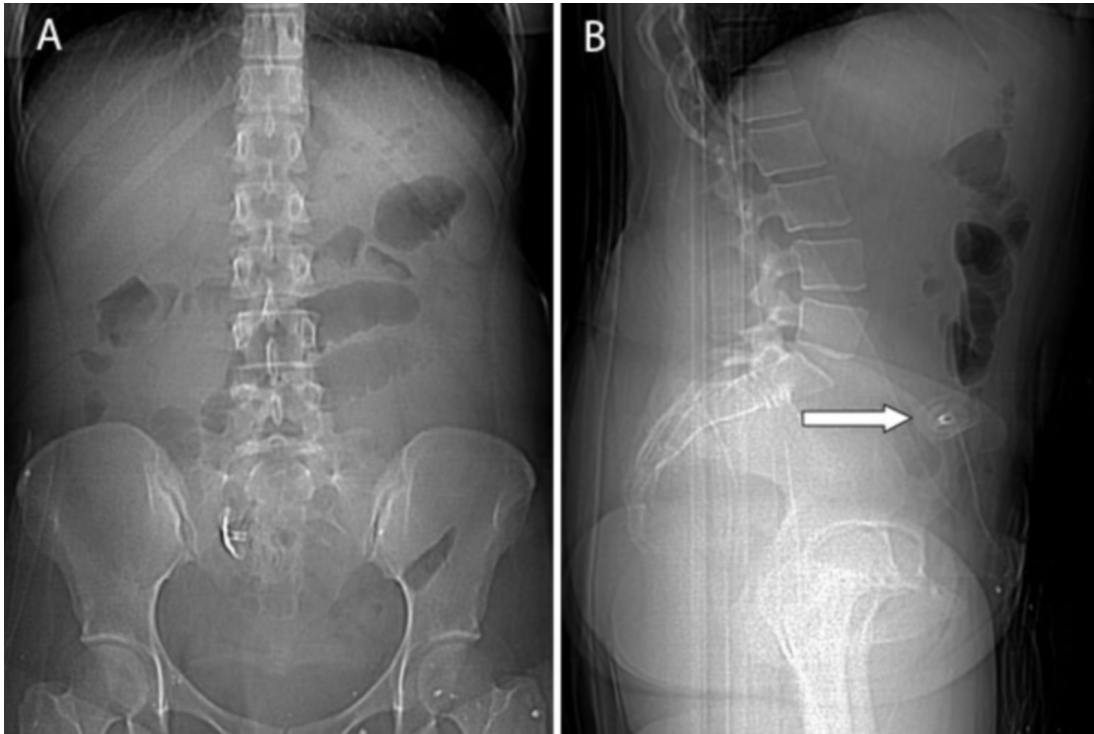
25-year-old woman with small bowel obstruction caused by migrated, deflated bioenteric intra-gastric balloon. (A) Radiograph shows the deflated gastric balloon in the lower abdomen and dilated small bowel. (B) Lateral CT scout shows the location of the balloon. Arrow points to the valve.
